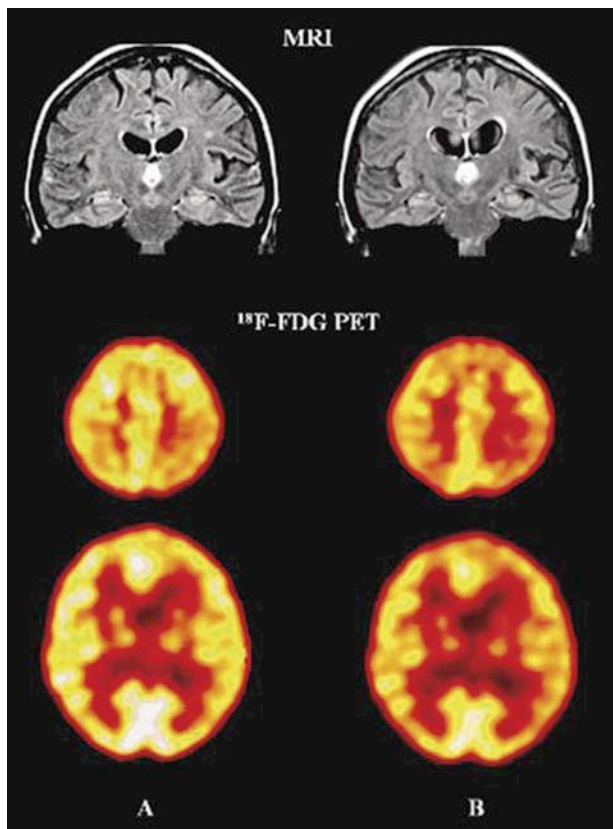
MRI scans shown atrophy of the left entorhinal cortex with relative sparing of the hippocampus. 18F-FDG PET scans showing progressive hypometabolism of both temporoparietal lobes and left frontal lobe between May 2005, already beginning in the left parietal cortex (A) and February 2008 (B).
